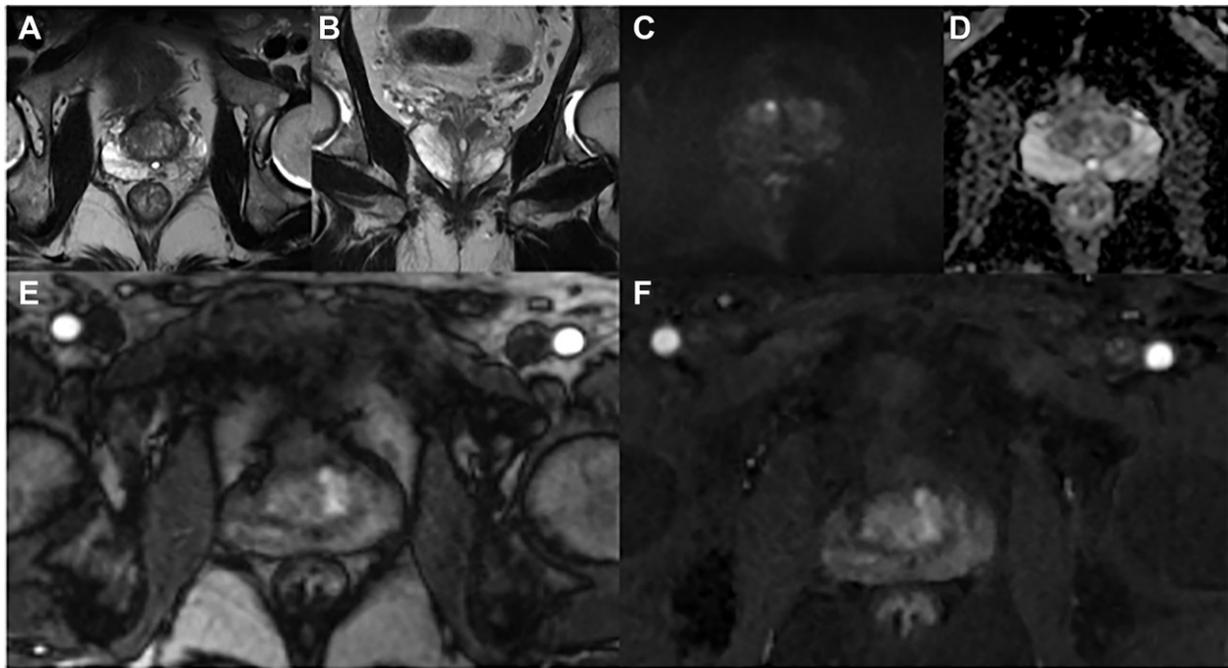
A case of multiparametric MRI of the prostate showing the difference between a prostate imaging quality (PI-QUAL) score of 4 and 5 in the same participant. Axial (A) and coronal (B) T2-weighted sequences are unremarkable as is the high-b-value sequence (C) and the apparent diffusion coefficient map (D). The dynamic contrast-enhanced sequences are shown before (E) and after (F) fat suppression, which makes the difference between PI-QUAL 4 and PI-QUAL 5 (ie, the vessels are clearly seen only after fat suppression). A PI-QUAL score of 4 indicates adequate image quality, and a score of 5 indicates optimal image quality.
